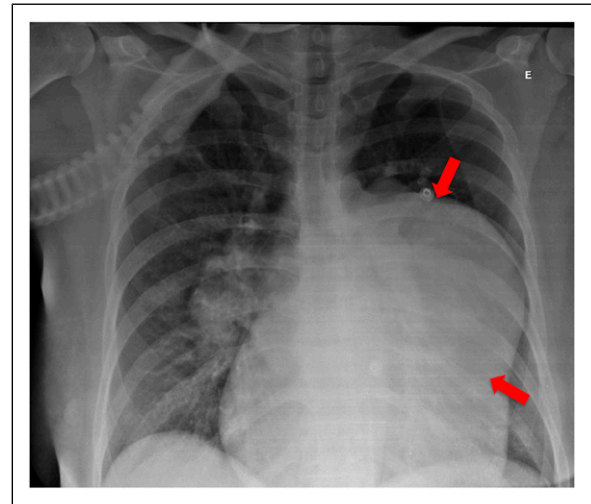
Chest X-ray demonstrating enlargement of the cardiac area, predominantly on the left side of the heart. (E denotes left). X-Ray performed in 2018.
